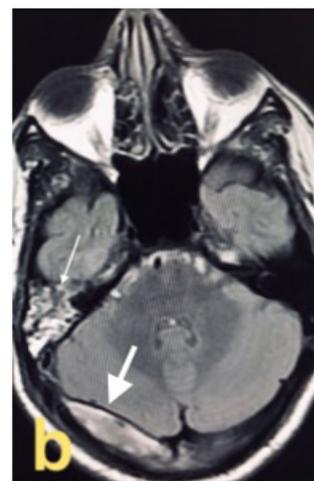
Axial T2 FLAIR of the brain showing similar signal characteristics involving the right mastoid air cells (denoted by thin white arrow) and right transverse sinus (denoted by thick white arrow).
